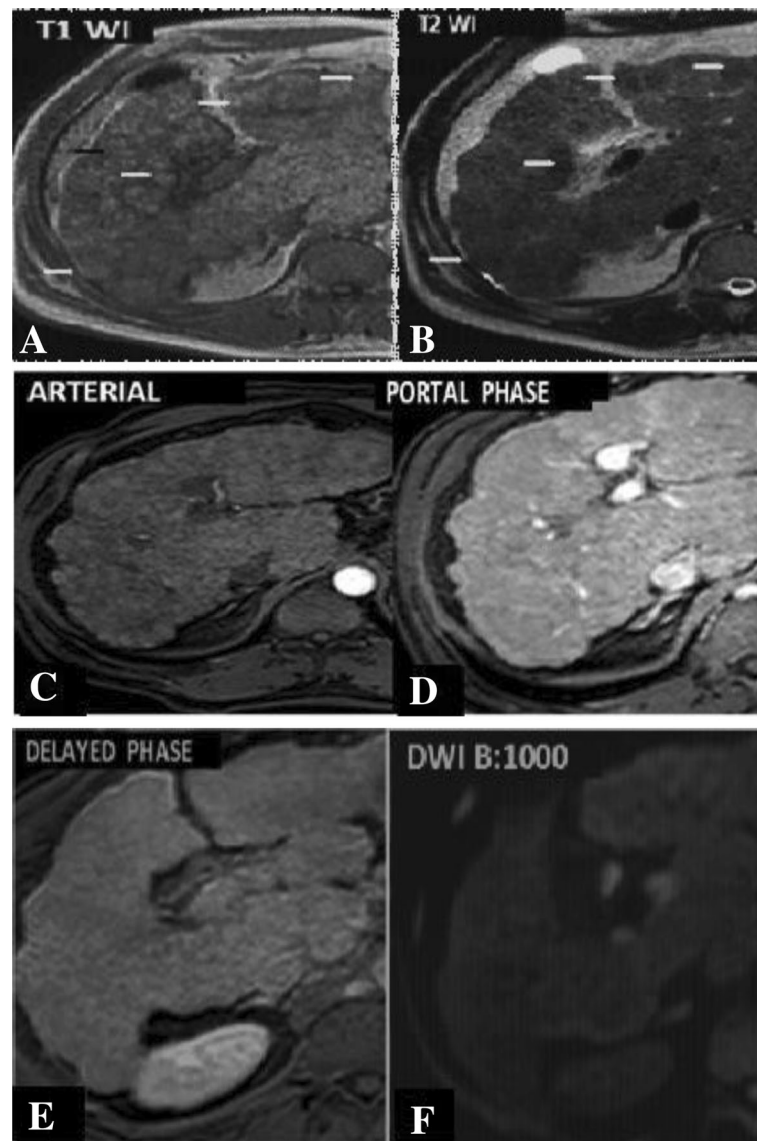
A male patient aged 63 years old presented with tender abdomen who underwent ultrasonography and revealed several small nodules and referred to the MRI unit for further evaluation. a An axial unenhanced T1WI shows multiple nodules of isointense signal similar to liver parenchyma. b An axial T2WI shows the lesion to be of low SI. c An axial post-contrast arterial phase image shows the lesion to be isointense. d, e An axial portal and delayed post-contrast image shows the lesions were also isointense with no contrast uptake. f DWI shows the lesions were isointense owing to free diffusion. Suggested MRI diagnosis: multiple regeneration nodules. Biopsy results: confirmed regeneration nodules
